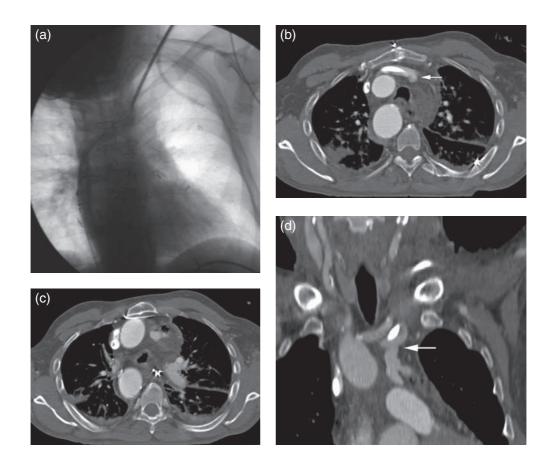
56-year-old man with heart–lung transplant 8 years previously. He developed renal insufficiency secondary to cyclosporine therapy. He presented for tunneled hemodialysis catheter. During insertion of the peel-away sheath the guidewire was bent and dilator pointed into the mediastinum. A quick hand-injected venogram showed regular flow of contrast through the brachiocephalic vein (a). Because of pain and an episode of hypotension a few hours later a CT was performed showing rupture of the left brachiocephalic vein (arrow, b) and a mediastinal hematoma with air from the recent catheter placement (c). The rupture in the trajectory of the traumatically inserted dilator is better visualized on coronal reconstruction (arrow, d). The patient was admitted to ICU for observation. He did well without any further intervention and left the hospital 2 days later.
